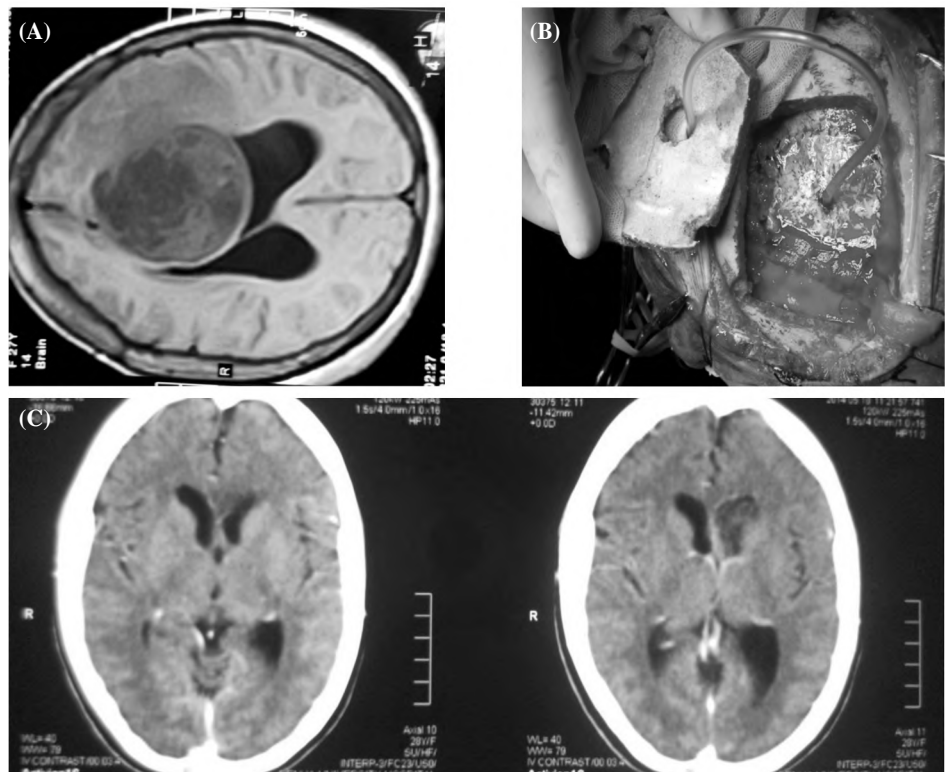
(A), Pre-operative T1 MRI brain without contrast showing giant heterogenous left lateral ventricular mass. (B), Intraoperative view showing the linear incision. (C), Post-operative CT brain showing total tumor removal.
